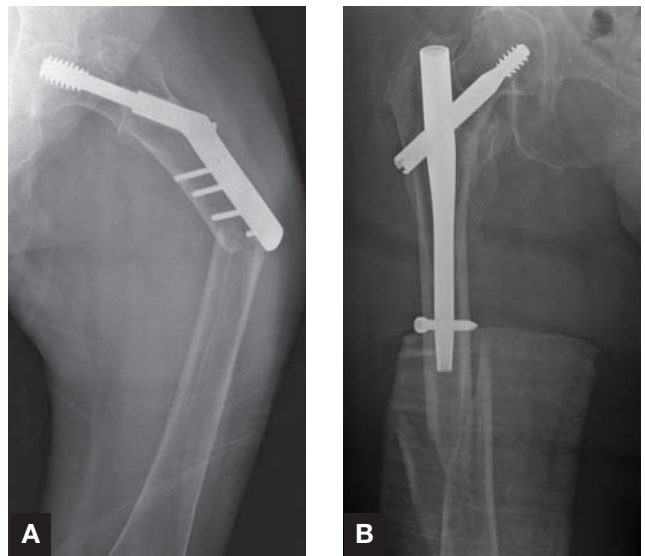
(A) Periprosthetic fracture at distal tip of dynamic hip screw. (B) Periprosthetic fracture at distal tip of short intramedullary nail. These 2 example radiographs are not from our patient cohort.
